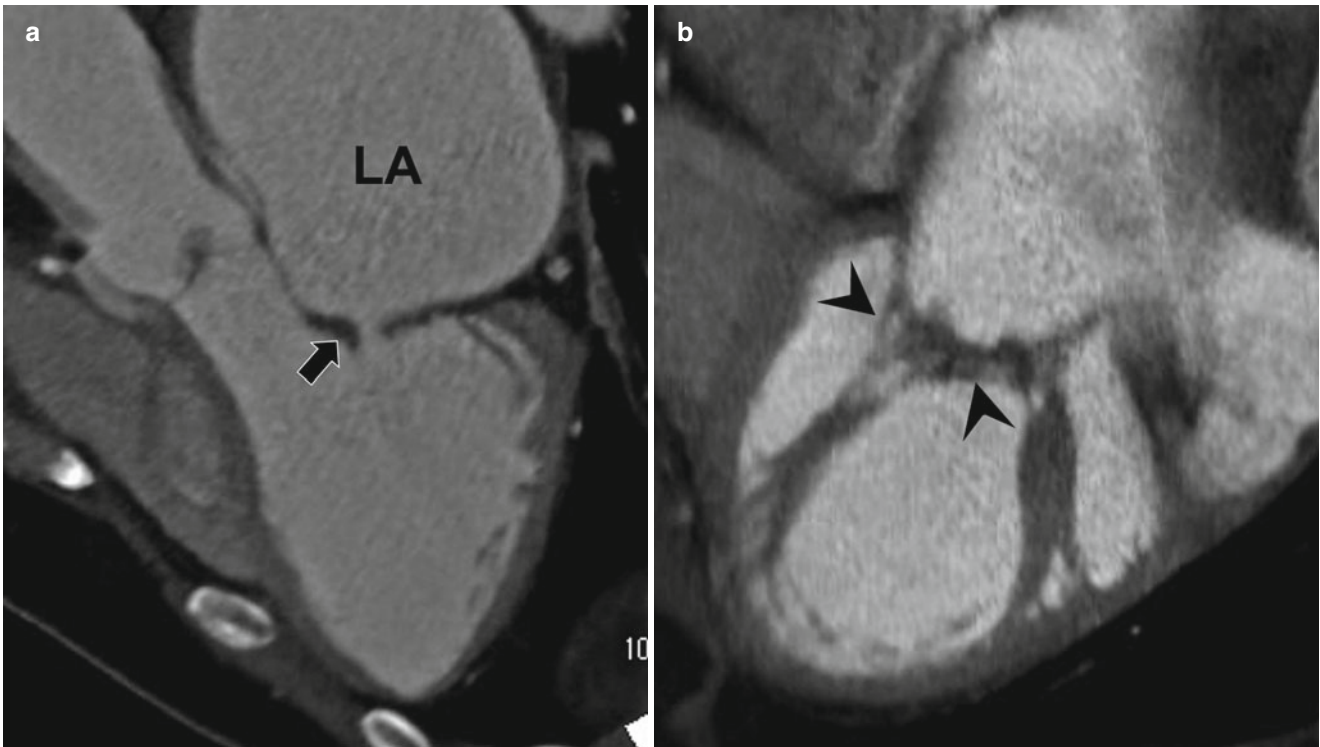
Rheumatic mitral stenosis. (a) Three-chamber view of CT shows thickening and doming of the mitral valve (MV). Valvular thickening is more prominent in the posterior leaflet and tip of the anterior
